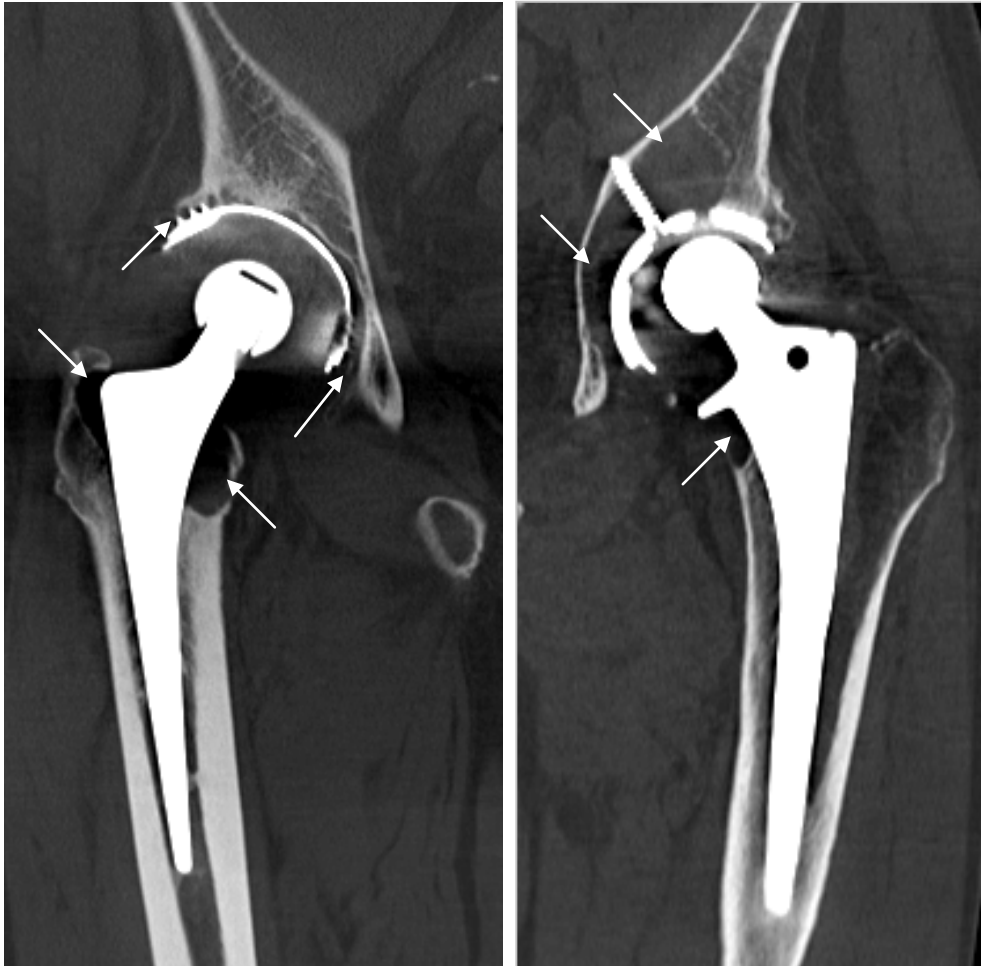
CT images derived from adapted CT protocol for use with 128-slice CT scan (Siemens SOMATOM DEFINITION AS+, Germany) with extended CT scale and automatic exposure control (AEC). The effective radiation dose was cut from 20.56 mGy down to 10.17 mGy without compromising the image quality. Shown are periprosthetic osteolytic lesions adjacent to both acetabular and femoral components (arrows).
